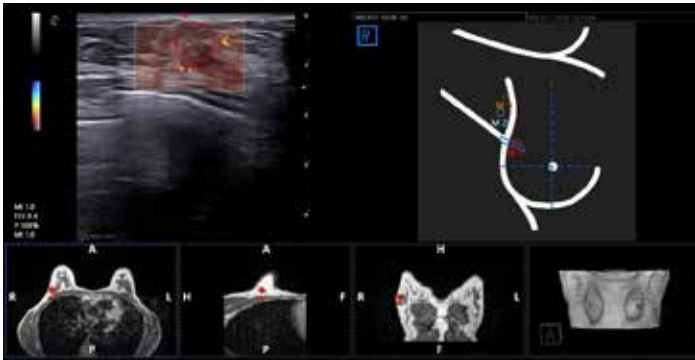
microV technology for the detection of very small flows, associated with BreastNav™MRI
